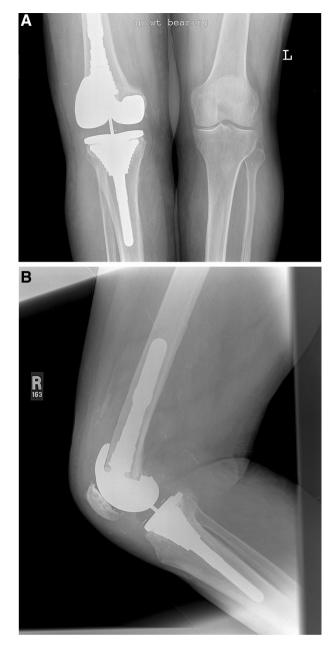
a AP and b lateral radiographs after total knee revision with tibial and femoral metaphyseal sleeves demonstrating stable osseoin-tegration
